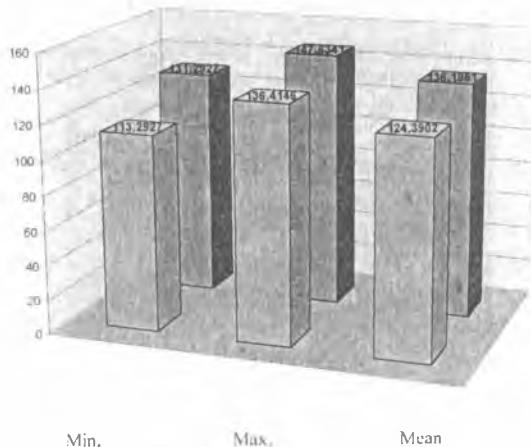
Average values of minimum, maximum and mean results of density measurements in cases of chronic fibrous periapical changes
